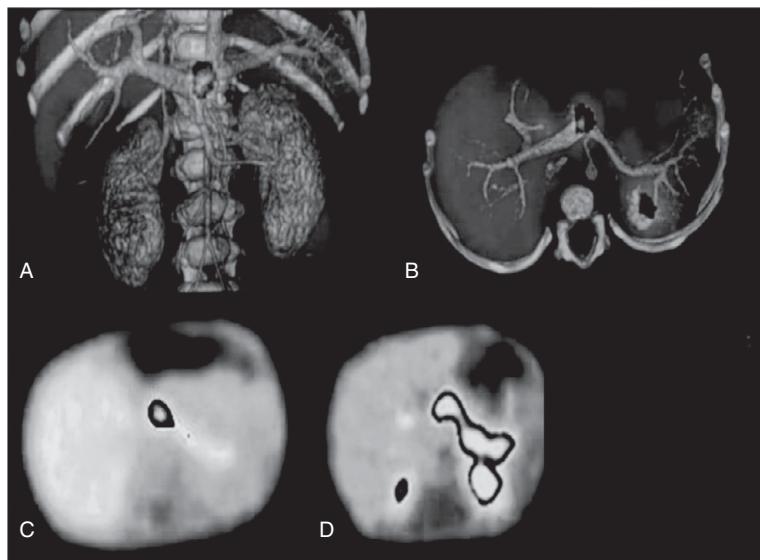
18 F-fluoro-L-DOPA PET-scan imaging in patients with HI. Focal form (A, B, C): PET-scan localizes accurately the focal lesion. A, B: 3D CT-scan reconstruction fused with PET imaging showing pancreatic uptake of the radiotracer to be almost exclusively located at the head of the pancreas. C: Transversal PET imaging in a suspected focal form. D: Transversal PET imaging in a suspected diffuse form showing uptake of the radiotracer appears in the whole pancreas. Adapted from (open access copyright) Arnoux JB, et al. Congenital hyperinsulinism: current trends in diagnosis and therapy. *Orphanet Journal of Rare Diseases* 2011;6:63
